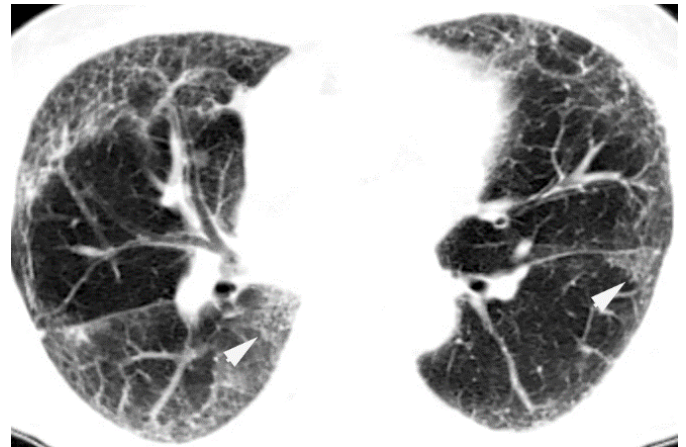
CT image of the patient's father demonstrating peripheral lower lobe predominant pulmonary fibrosis. The fibrosis is usual interstitial pneumonia with traction bronchiectasis and honeycombing. Arrows are pointing at honeycombing, which can mimic cystic changes.
